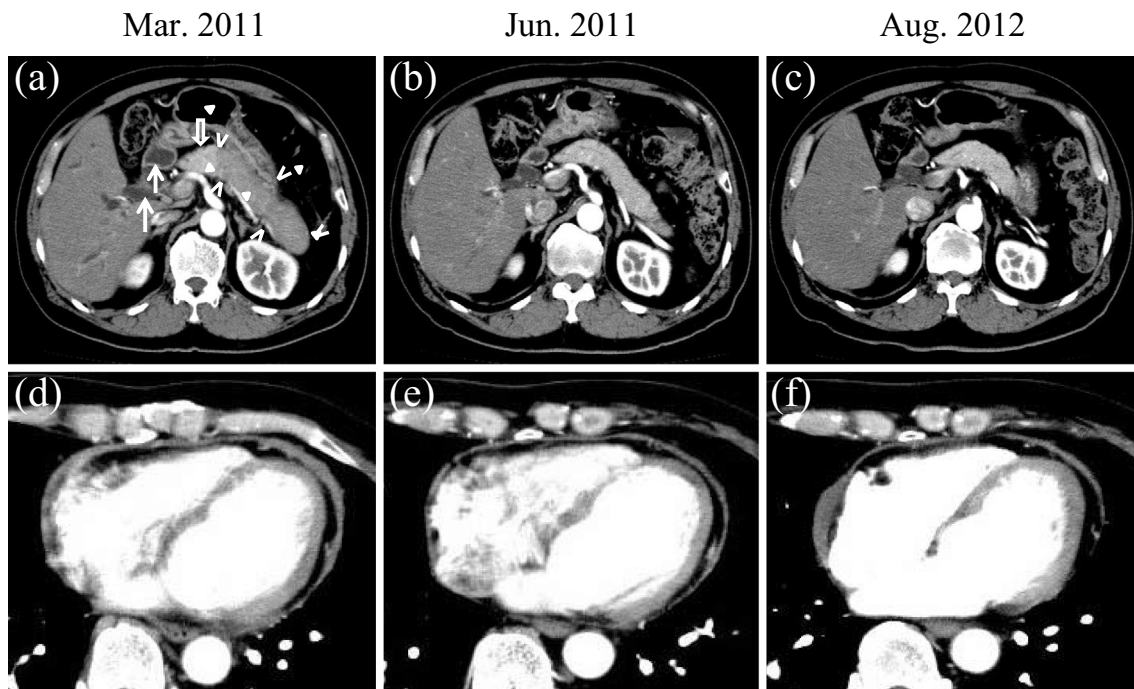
Sequential abdominal and chest computed tomography. (a) Extra/intrahepatic biliary tract dilatation, lower bile duct stricture and wall thickening (arrows) with an enlarged pancreas (arrowheads) are shown. The enlarged pancreatic parenchyma exhibited decreased enhancement compared with the normal adjacent pancreatic parenchyma (open arrow). (b, c) After corticosteroid therapy, the bile duct thickening and pancreatic swelling gradually resolved. (d) Pericardial thickening was observed on admission. The maximum pericardial thickness over the anterior surface of the heart was 6.3mm. (e, f) Following corticosteroid therapy, the pericardial thickening gradually decreased. The maximum pericardial thickness was 3.8 and 3.6 mm, respectively.
